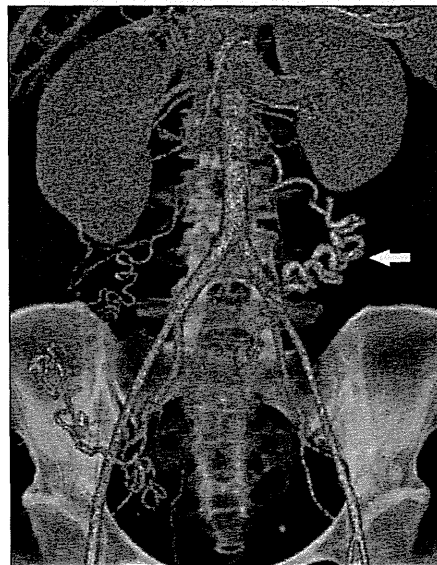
Reformatted computed tomography scan on admission at 2 days after delivery revealed the left tortuous ovarian artery with aneurysm formation (arrow).
